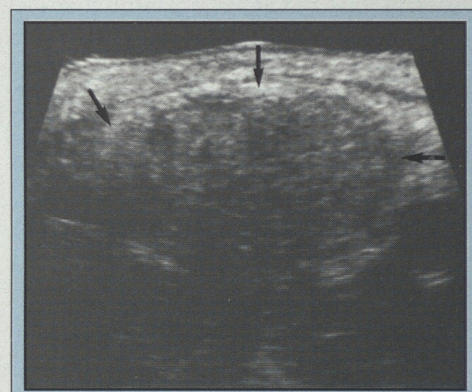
Transverse sonogram showing diffuse inflammatory enlargement of the submandibular gland (arrows) with heterogeneous parenchymal echoes. No obvious calculus or focal abscess detected.
